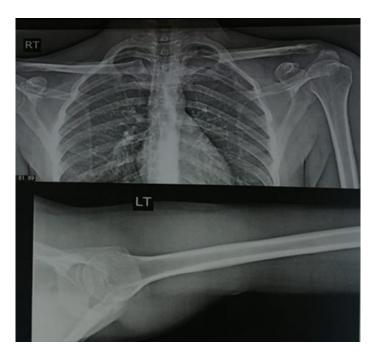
Immediate postoperative x-rays of case 2.
